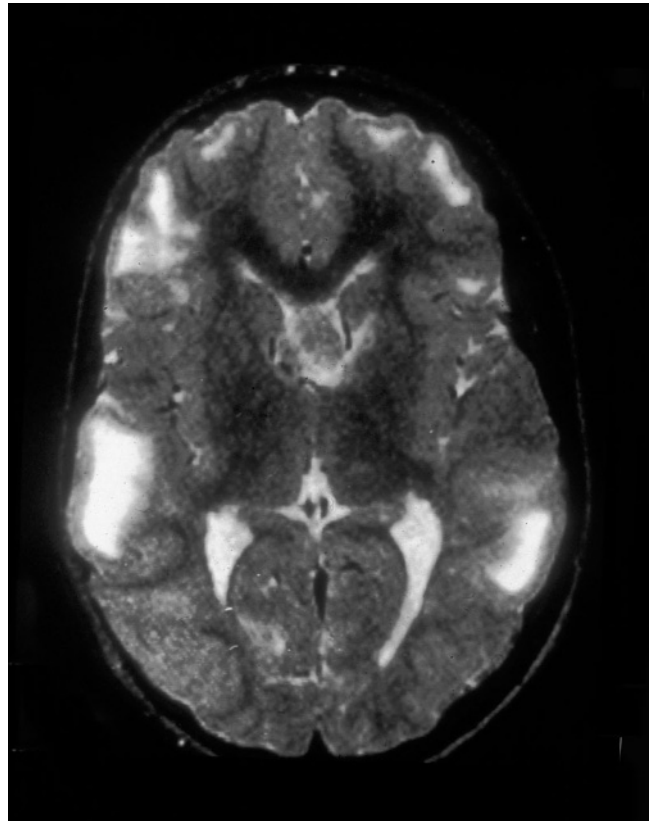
Noncontrast T_2 -weighted magnetic resonance image from a child with tuberous sclerosis demonstrates extensive high-signal cortical lesions typical of tuberous sclerosis. Reproduced with permission from Miller VS, Roach ES: Neurocutaneous syndromes, in Bradley WG, Daroff RB, Fenichel GM, Marsden CD (eds): *Neurology in Clinical Practice*, 3rd ed. Newton, MA, Butterworth-Heinemann, 1999, 1665-1700.
